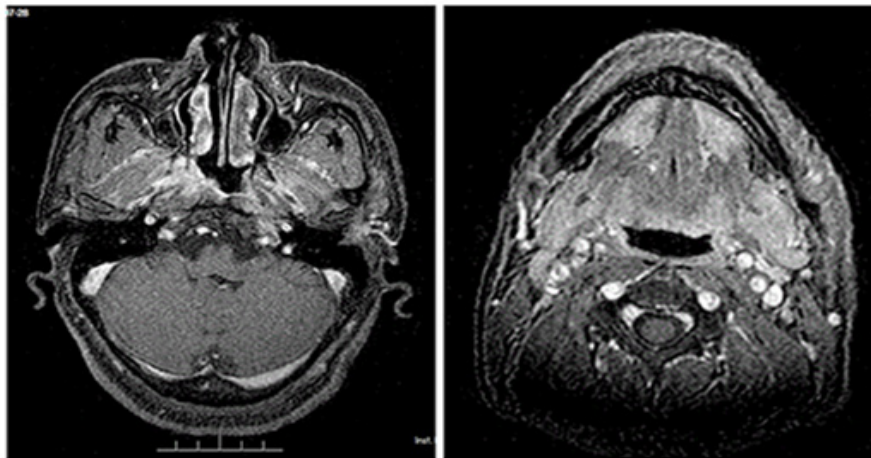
MRI images of the nasopharyngeal mass(left) and neck lymph nodes(right) after concurrent chemoradiotherapy.
